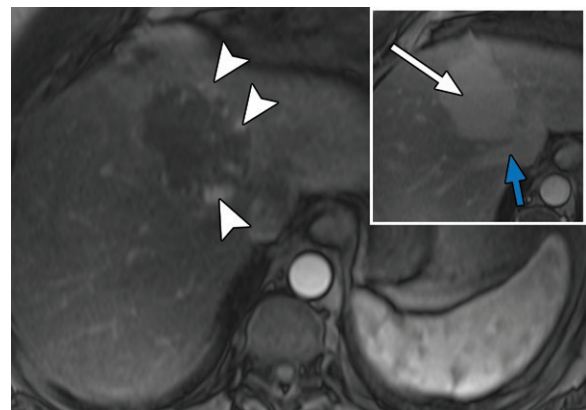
HBP interpretation in the context of blood pool signal intensity in a 50-year-old woman with indeterminate liver lesions. Axial T1-weighted arterial phase MR image shows peripheral nodular discontinuous APHE (arrowheads) in a segment VIII/IVa liver lesion, characteristic of a cavernous hemangioma. T1-weighted HBP image at 60 minutes with gadobenate (inset) shows diffuse hyperintensity of the mass (white arrow) compared with background liver, atypical of a hemangioma in the HBP. However, the blood pool (blue arrow) is similarly hyperintense owing to severe hepatic steatosis. The hemangioma should be recognized as following blood pool signal intensity rather than retaining contrast material with HBP imaging.
